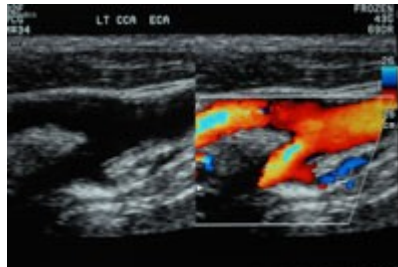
Vascular ultrasound image of the carotid bifurcation (Keywestdiagnostics, 2007).
